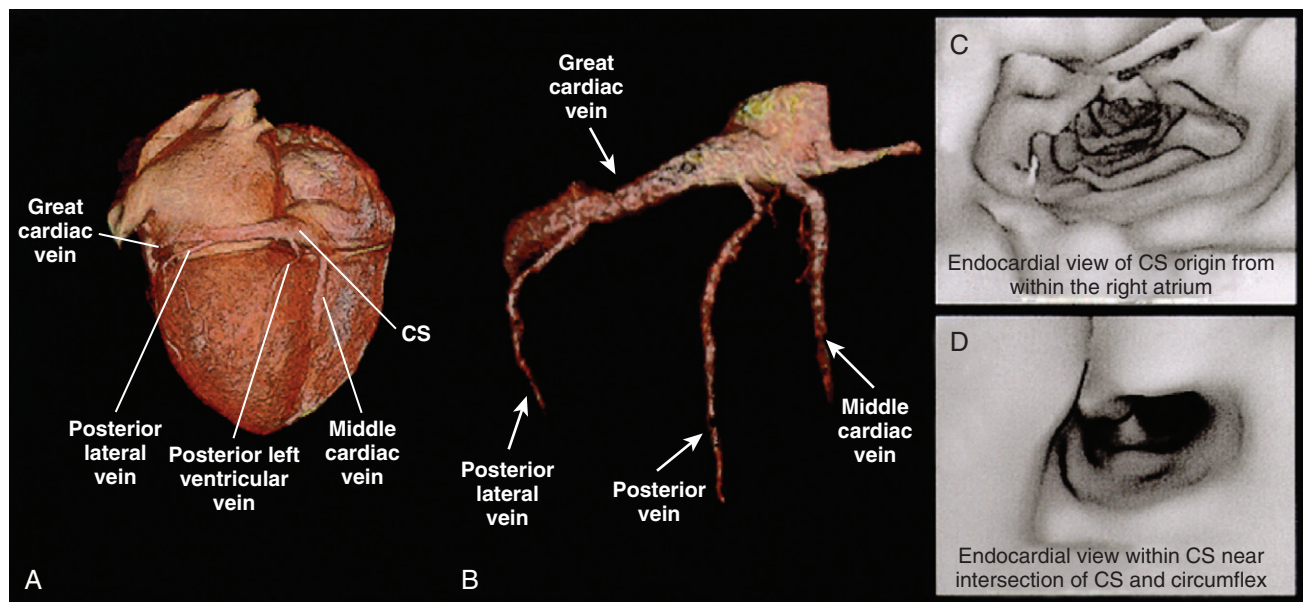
Three-dimensional images of the left ventricle (LV) and coronary sinus (CS). A, Endocardial images of the CS also can be obtained using post-processing segmentation algorithms. A three-dimensional image of the LV and the CS with its branches in a patient obtained using CT (16 slice, light speed ultra). B, Post-processing segmentation algorithms used to show three-dimensional images of the CS alone. C and D, Endocardial views of the CS at two different locations. These imaging techniques could help create a roadmap for CS lead placement in patients undergoing cardiac resynchronization therapy. (From Sra J, Krum D, Okerlund D, et al: *Three-dimensional and endocardial imaging of the coronary sinus for cardiac resynchronization therapy*, *J Cardiovasc Electrophysiol* 15:1109, 2004.)
